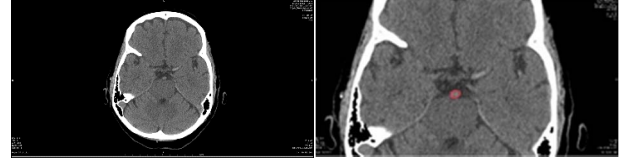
Example of CT image and the boundary of the thrombus
